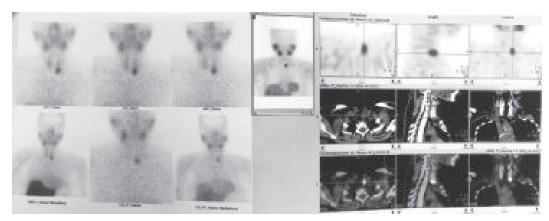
Parathyroid scintigraphy showing parathyroid adenoma / hyperplasia in left lower part
